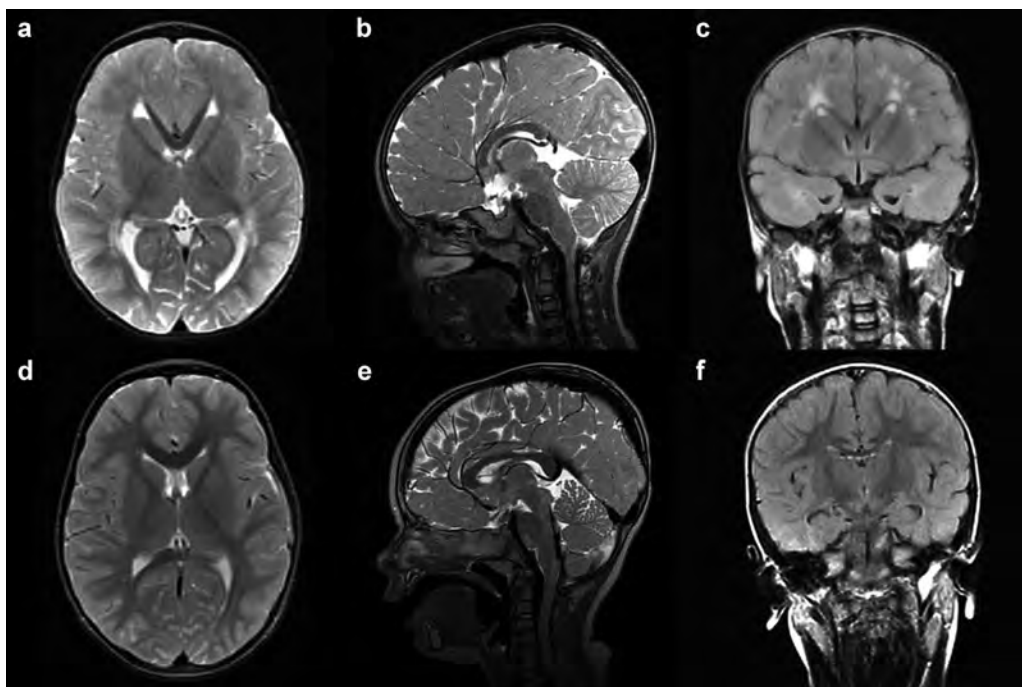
T2-weighted (a,b) and FLAIR (c) patient images showing a small genu, absent rostrum, and lamina terminalis (b) and abnormal “steep” course (a,c) of the corpus callosum. An abnormal fornix and aberrant orientation of the cingulum gyrus, due to absence of the rostral dorsal part can be noted (b). An abnormal, straightened course of the frontal branches of the anterior cerebral artery, including the pericallosal arteries (b) is seen. On FLAIR image, extensive confluent hyperintensities of the periventricular white matter, which can be interpreted as confluent leukoencephalopathy, can be appreciated (c). Also, bilateral underdevelopment of the hippocampal region is present (c). T2-weighted axial and sagittal (d,e) and coronal FLAIR (f) image of age-matched control.
